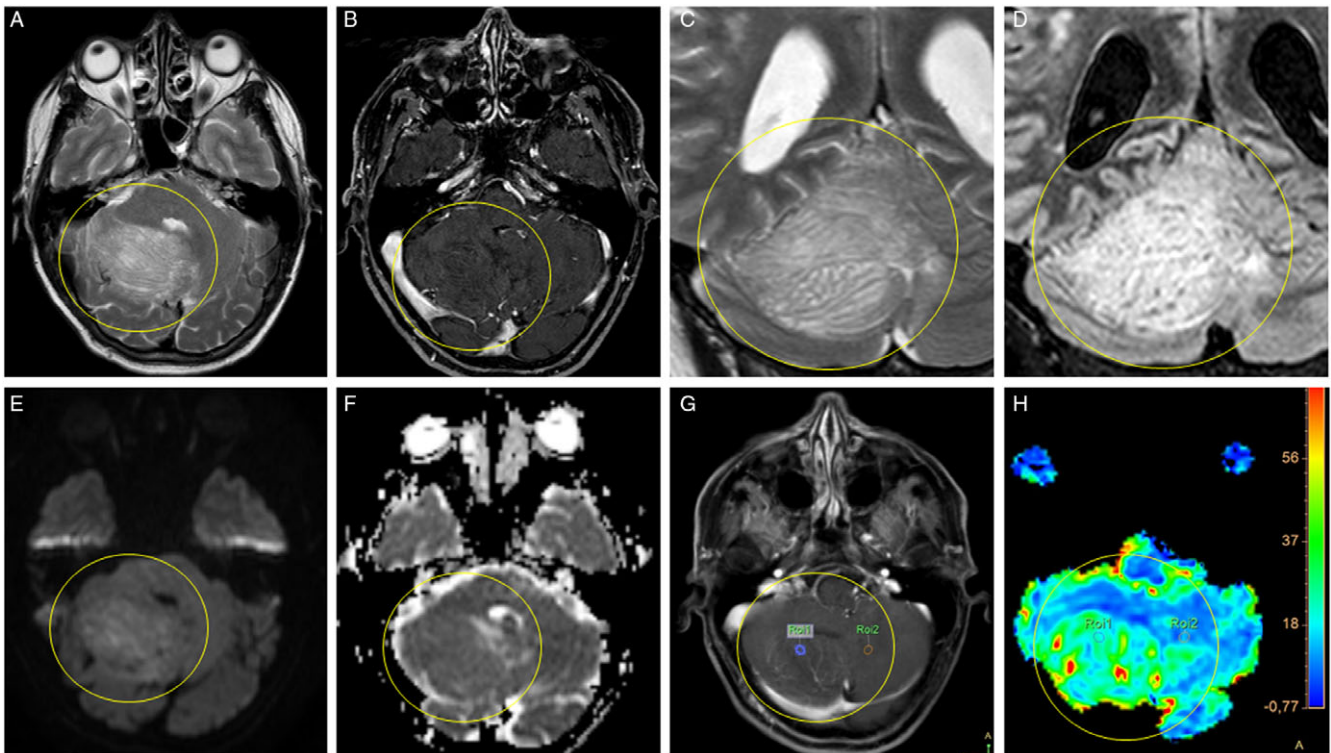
Brain MRI findings in relation to dysplastic cerebellar gangliocytoma or Lhermitte-Duclos disease. The lesion is shown surrounded by a yellow circle. (A) Axial T2WI. Non-infiltrating hyperintense lesion in the right cerebellar hemisphere, without peripheral edema. (B) Axial contrast-enhanced T1WI. The lesion is hypointense, without contrast enhancement, contacting the structures of the posterior fossa and obliterating the fourth ventricle. (C-D) Coronal T2WI and FLAIR images. The lesion shows a striated or “corduroy” appearance. Note also the widening and thickening of the cerebellar folia. (E-F) The lesion does not show restricted diffusion on Diffusion Weighted Imaging (DWI) or Apparent Diffusion Coefficient (ADC) maps, suggesting low cell density within the lesion. DWI hyperintensity in E is due to a subtle T2 shine-through effect. (G-H) A significant increase in perfusion values inside the lesion is not detected either.
